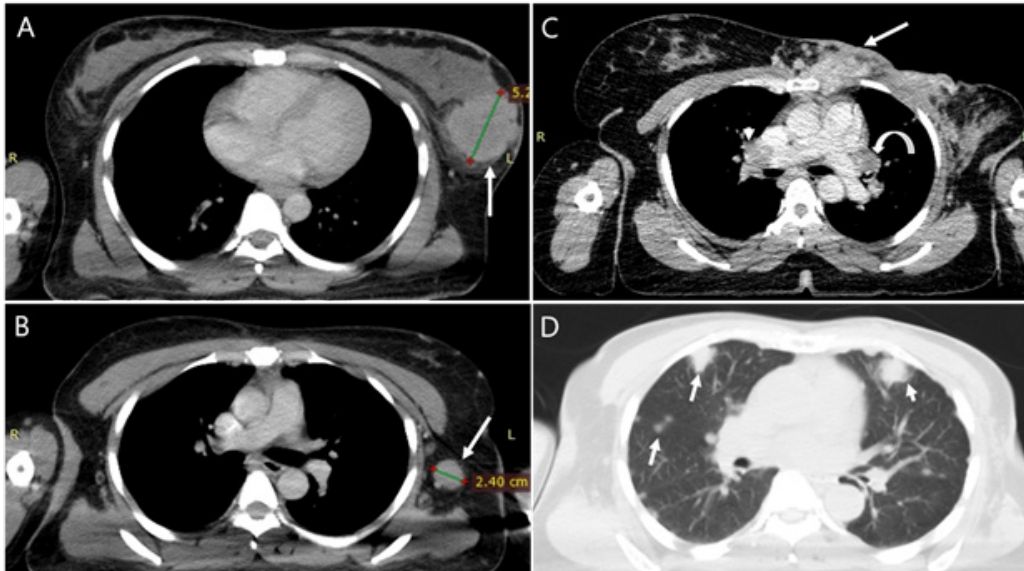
A, B. Contrast-enhanced axial CT of a 40-year-old female with a left breast cancer. In A, there is a huge left breast mass with long axis more than 5cm (white arrow). In B, there is a bulky Berg’s level I ipsilateral axillary lymph node (white arrow). C. Axial contrast-enhanced CT of a 44-year-old woman with left breast cancer and history of left mastectomy. There is tumor infiltration of the skin and chest wall (straight arrow), a left hilar lymphadenopathy (curved arrow) and pulmonary embolism at the distal right pulmonary artery (arrowhead). D. Axial CT, lung window of a 53-year-old woman with a left breast cancer. There are multiple solid lung nodules of different sizes in a random distribution
